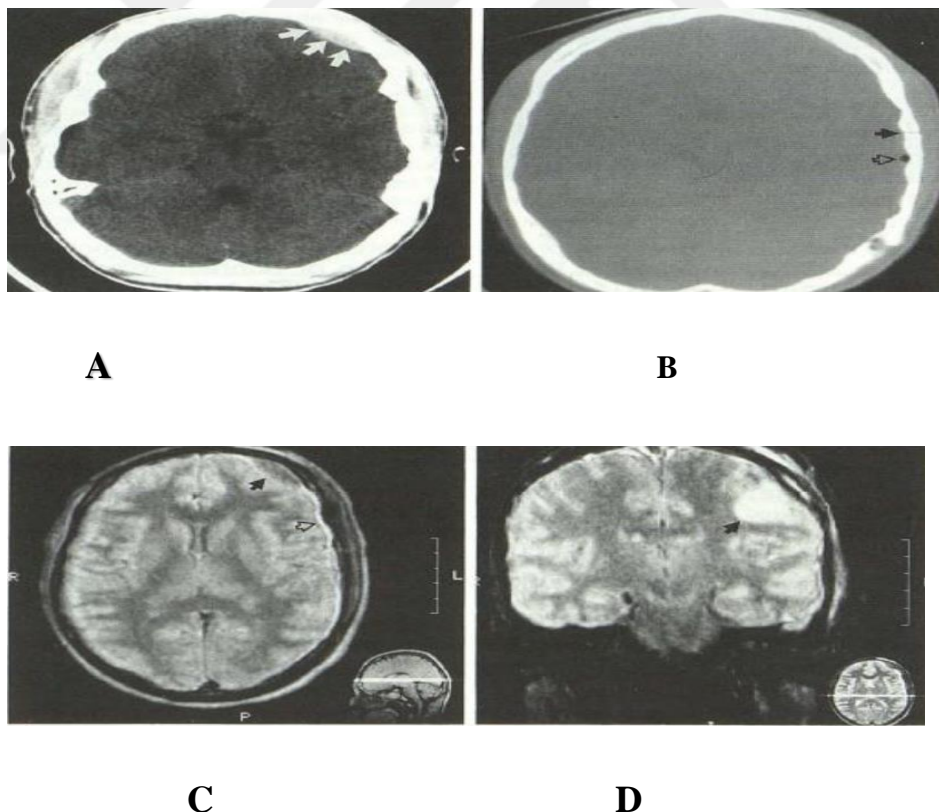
A and B shows the skull-fracture and hemorrhage legion of the injury while C and D refer to MRI images of the same case but after 1 day of the injuries and without ability to show the fracture significantly.
